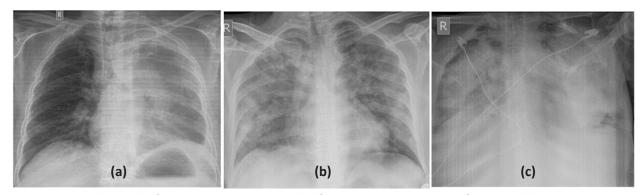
Chest radiography of three COVID-19 patients with different imaging patterns: a. Diffuse ground glass opacity involving the unilateral left lung (0-2, 0-2, 0-2; score 6); b. Diffuse ground glass opacity involving the bilateral lungs (2-2, 2-2, 2-2; score 12); c. Diffuse bilateral consolidation involving bilateral lungs with air Broncho gram (2-2, 2-2, 2-2; score 12).
